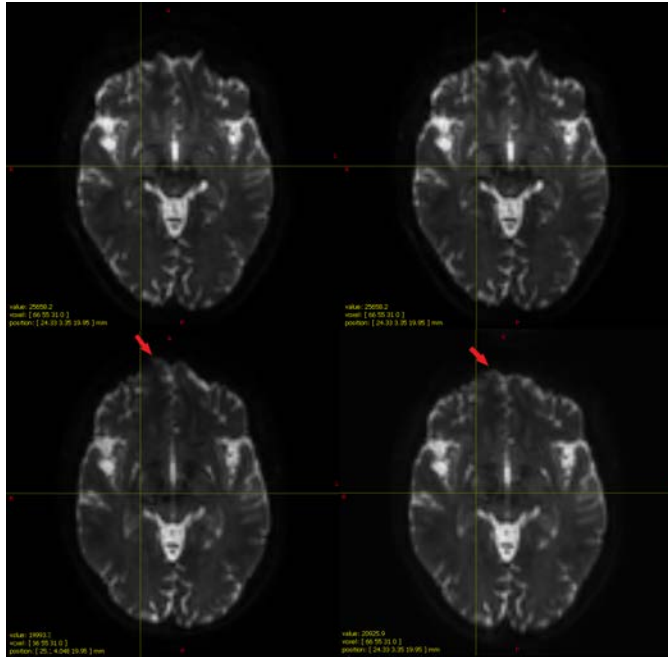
Axial view of the same slice for: DWI with AP-phase encoding (top left), DWI with PA-phase encoding (top right), integration between AP and PA sequences (bottom left), integrated DWI image after the preprocessing step (bottom right). The red arrow points to a region in which it is possible to see an image improvement thanks to these correction steps.
